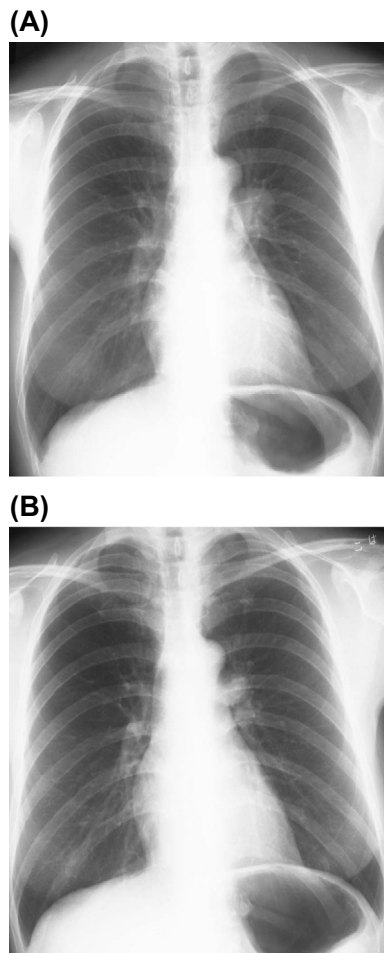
(A) The initial chest roentgenogram revealed a round mass in the left hilum. (B) A chest roentgenogram taken about a year ago revealed a slight lesion in the same area, which had clearly grown rapidly in the past year.
